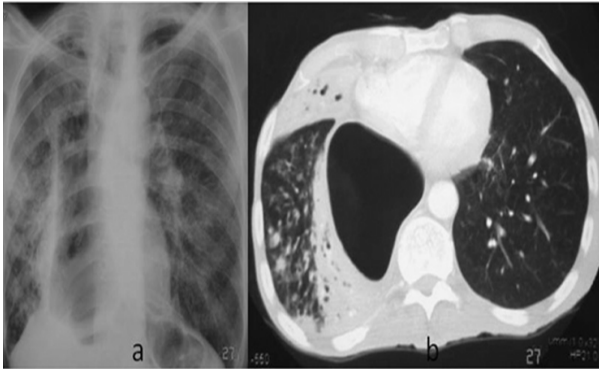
A) In the chest X-ray of the case, pneumonic infiltrations are seen in right middle and lower zones. B) In thoracic CT, right hemithorax shows serious pneumonic consolidated fields in the dilated stomach and surrounding pulmonary parenchyma.
